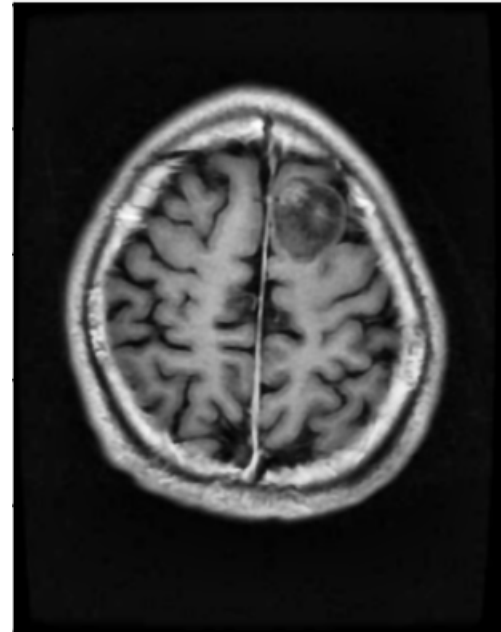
Original input MRI
